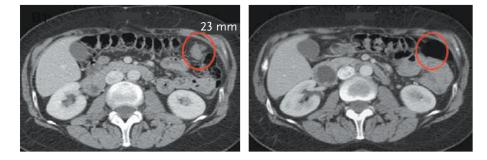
Regression of an ovarian cancer in response to treatment with the PARP inhibitor, olaparib; the patient had an inherited mutation of the *BRCA1* gene. The tumor disappeared completely in these computerized tomography (CT) scans of the abdomen (red circles) (Fong et al., 2009). Unfortunately, however, only about half of the *BRCA* mutant ovarian cancer patients responded to olaparib, the response was rarely complete, and the duration of response was 8 months at best (Fong et al., 2010).
